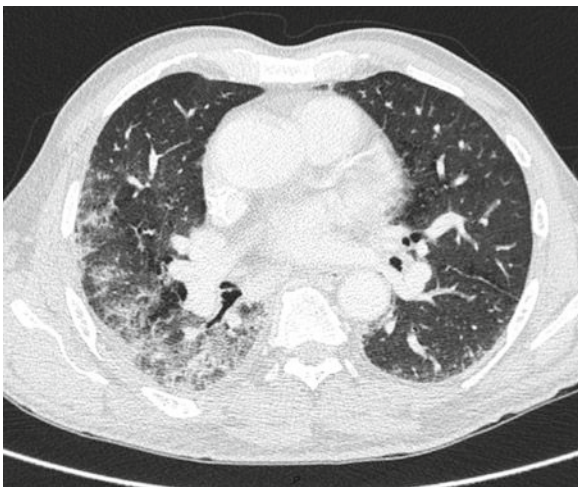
High-resolution computed tomography (HRCT) of the lungs, which ruled out pulmonary embolism and showed bilateral interstitial infiltrates with ground-glass opacities and pleural thickening
